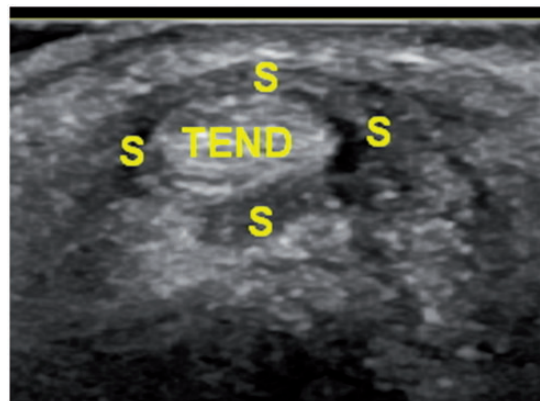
Cross-sectional ultrasound image of normal extensor carpi ulnaris (ECU) tendon (Tend) encircled by the synovial sheath (S).
